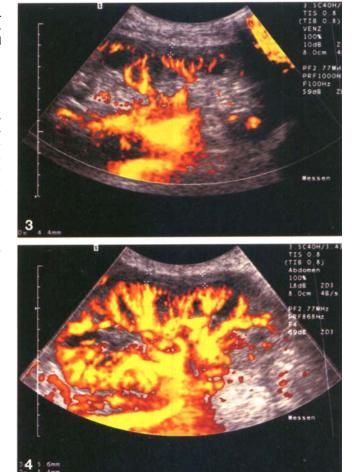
Power Doppler image of a female patient showing reduced POV (32%). PI and RI were normal: the creatinine level ranged from 1.3 to 1.5 PVD was slightly increased. Biopsy showed minor changes due to chronic transplant rejection. Extrarenal artifacts are due to small bowel movements
